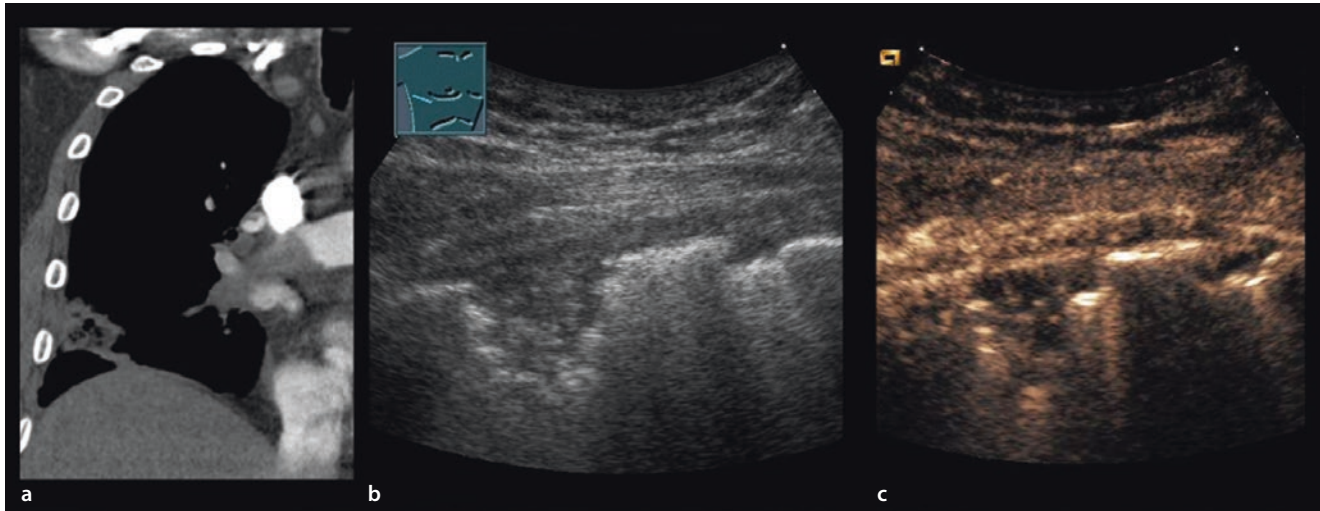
a Man with a confirmed central pulmonary embolism and a peripheral consolidation on computed tomography. b The B-mode ultrasound image reveals a peripheral hypoechoic consolidation.
